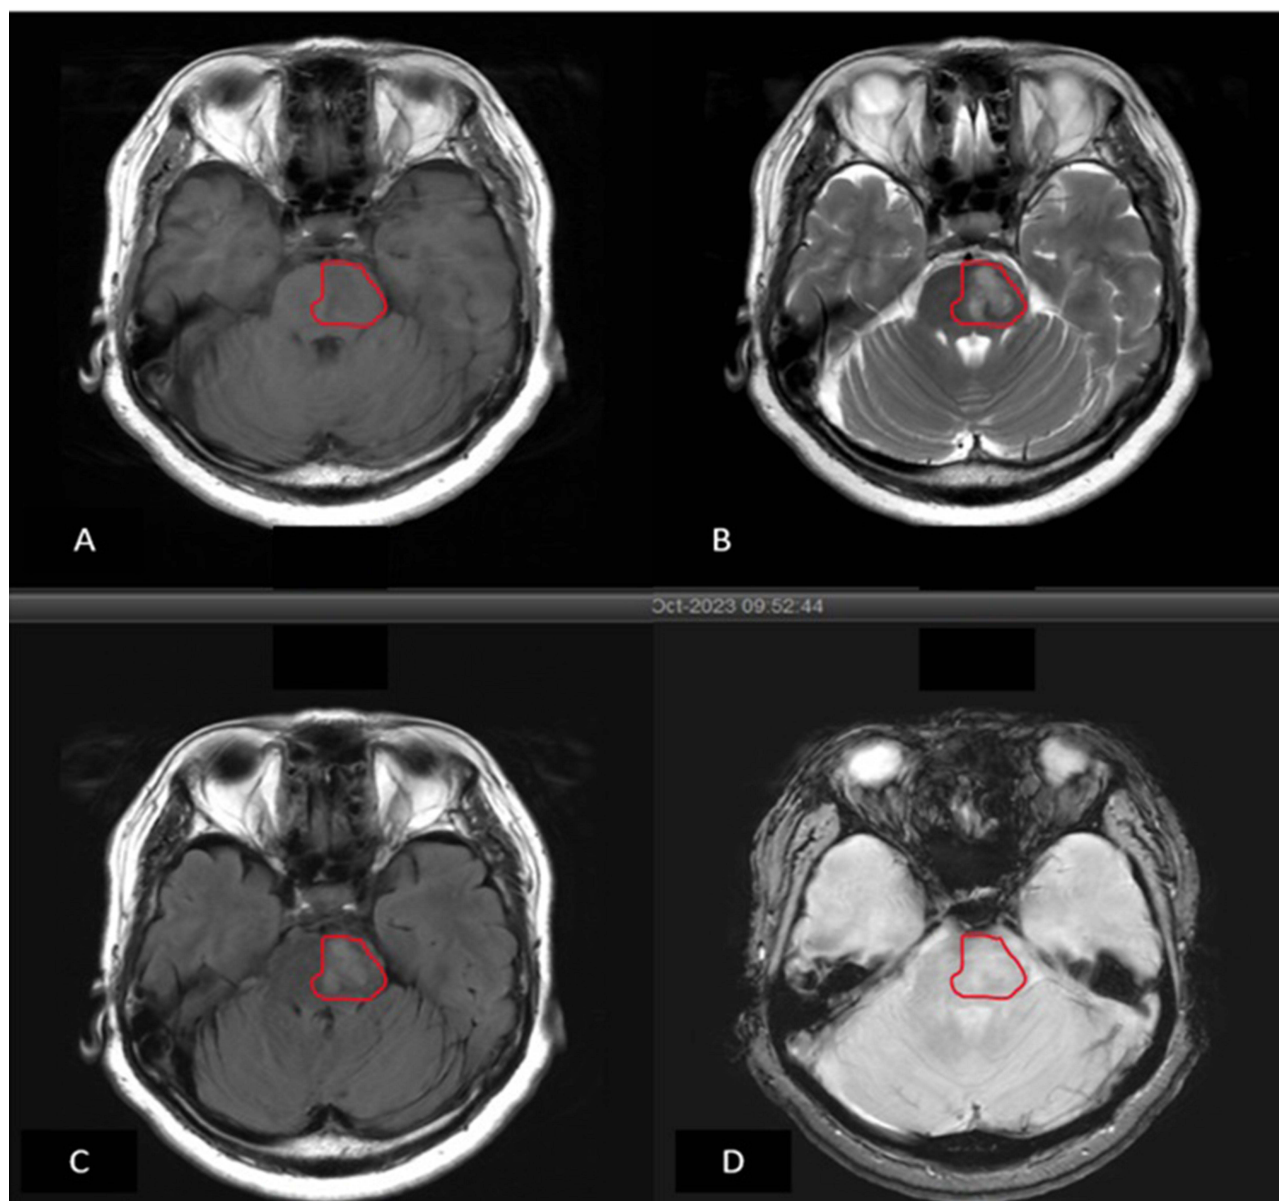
Standard MRI sequences in a 64-year-old female presenting with hemiparesis and dysarthria. MRI shows a pontine lesion (red circle) that appears slight hypointense in T1WI (A), hyperintense in T2WI (B) and FLAIR (C), with no dark area (blooming) on SWI (D), confirming acute ischemic stroke with no hemorrhagic transformation.
